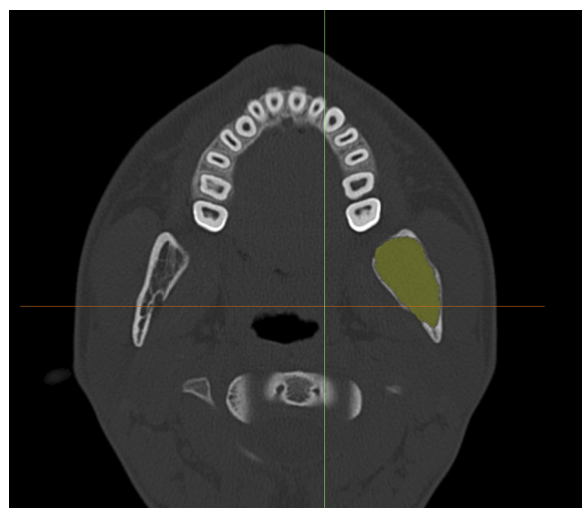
Three-dimensional volume analysis using computed tomography CT. Cross-sectional CT images of each lesion were demarcated, and the demarcated images filled up to reconstruct the 3-dimensional structures. Volume was measured using the Mimics 13.1 (Materialise NV, Leuven, Belgium) software program.
